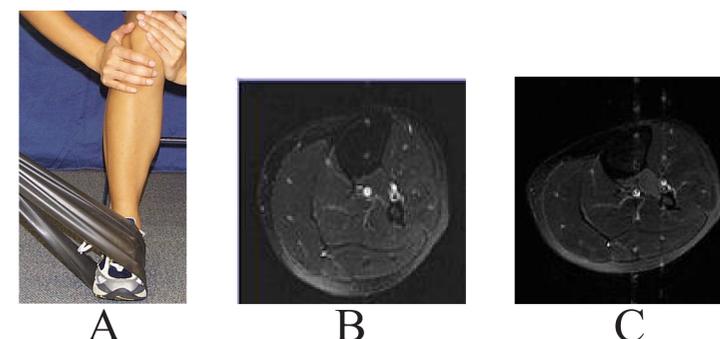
(a) Plantar Foot Adduction Exercise; Transaxial MRI of the left lower leg (b) before exercise, (c) after exercise.
